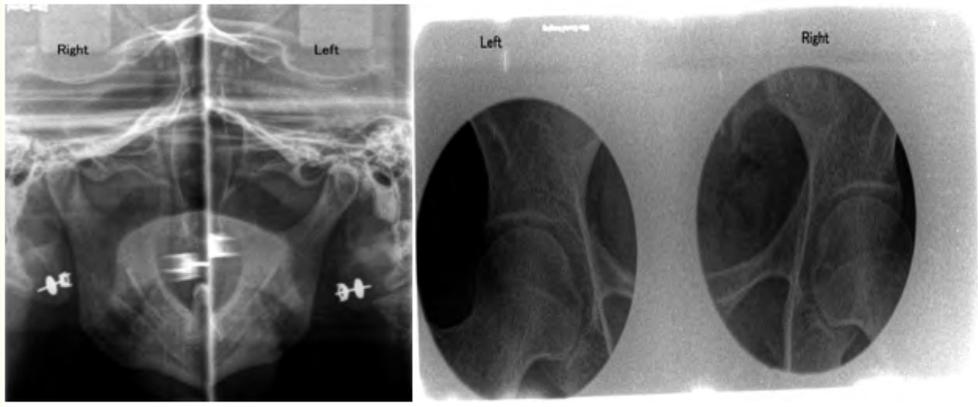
X-ray of hip joints of the patient.
